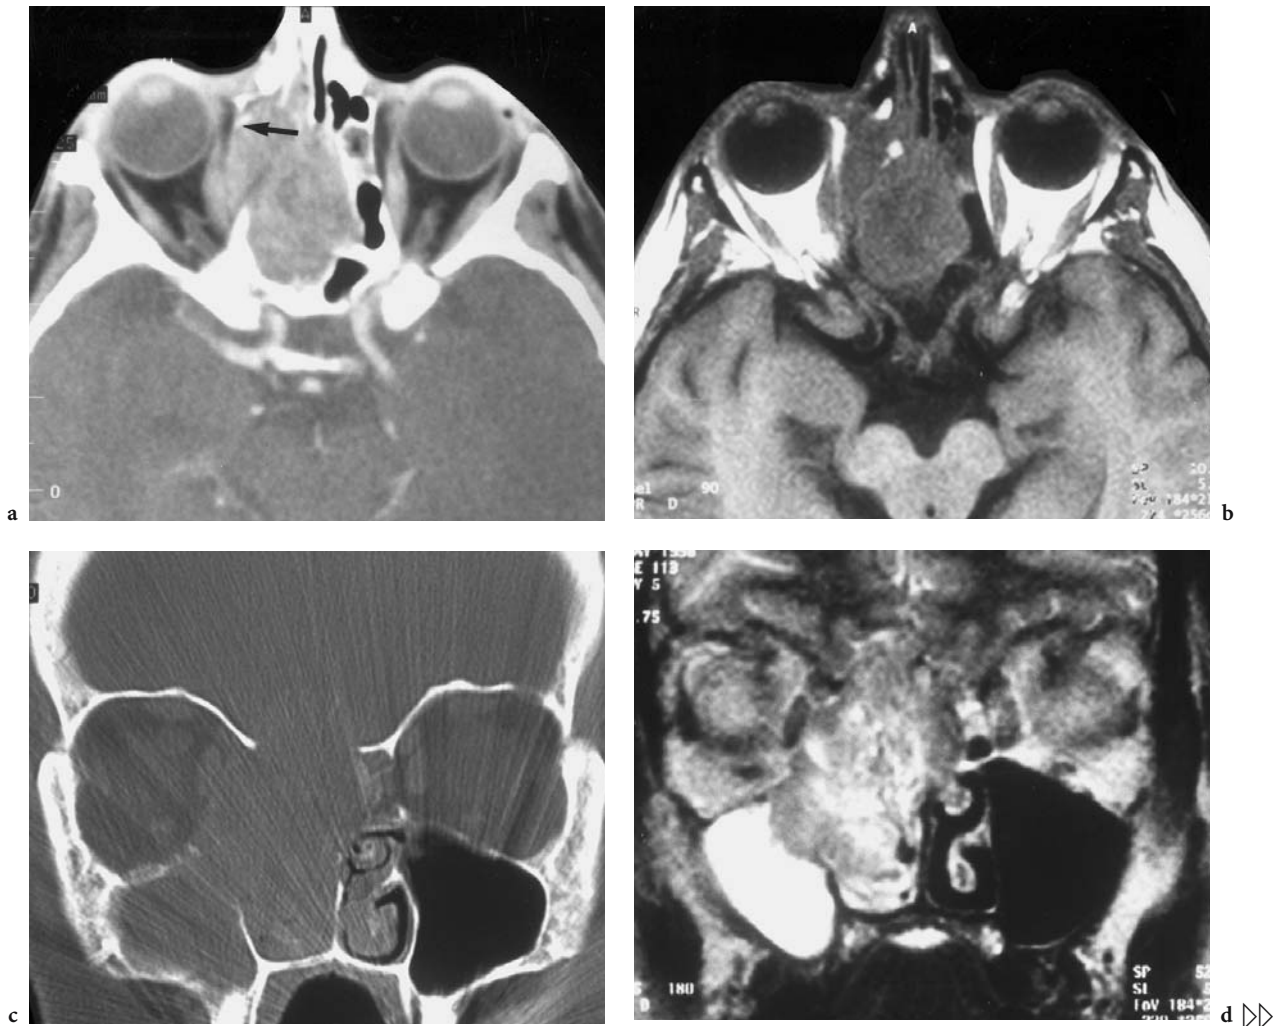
A 65-year-old woman, presenting with slight proptosis of the right eye, diffuse pressure in the orbital region, and difficulty in nasal breathing for a period of several months. Diagnosis: esthesioneuroblastoma. a Axial contrast-enhanced CT demonstrating a very large tumor occupying predominantly the right ethmoid and sphenoid sinuses and crossing the midline. Although the medial orbital wall is destroyed and intraorbital extraconal tumor expansion with medial dislocation of the medial rectus muscle is visualized, the presence of a small fat border (*arrow*) indicates sparing of the periorbit. b Corresponding T1-weighted native MRI, showing intraorbital expansion less conclusively, but providing a superior view of the periorbital growth. Note the expansion to the bony optic canal. c Coronal CT in the bone window, demonstrating additional destruction of the skull base and craniocaudal expansion of the tumor into the entire right nasal cavity. d Corresponding T2-weighted MRI with excellent differentiation between the mixed solid and necrotic tumor with slight high intensity and the bright signal of congestion due to maxillary mucus, but with only poor differentiation between tumor and brain parenchyma/gray matter. e-h see next page
